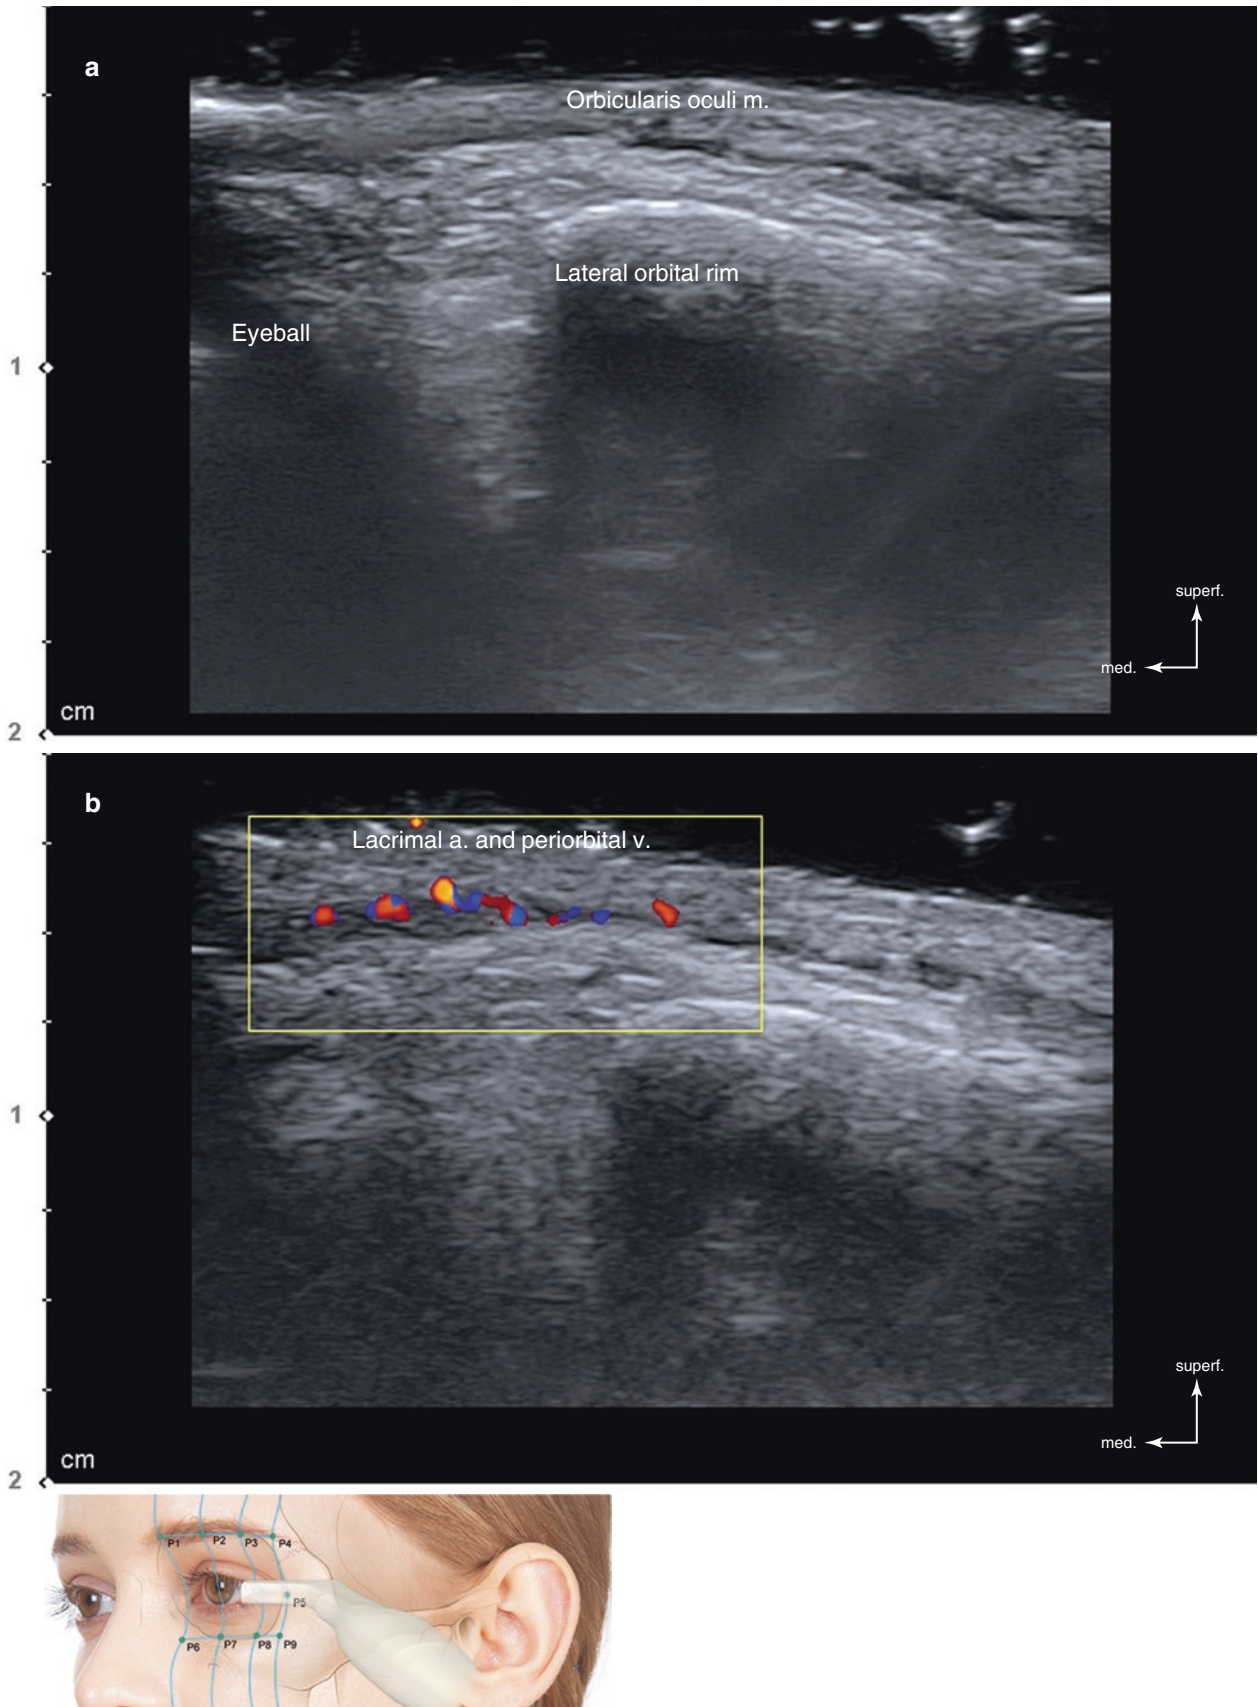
Ultrasonography on the lateral orbital rim at the level of the lateral canthus (P5). (a) B mode (transverse view, 15 MHz by linear transducer), (b) Doppler mode (transverse view, 15 MHz by linear
